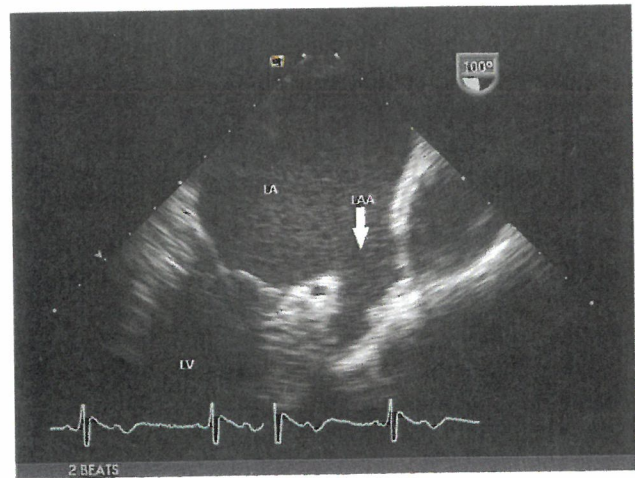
Transesophageal echocardiogram. The transducer is posterior to the heart, and the left atrium (LA) and left atrial appendage (LAA, arrow) are more easily seen than with transthoracic echocardiography, showing an absence of thrombus in the appendage. LV = left ventricle.
